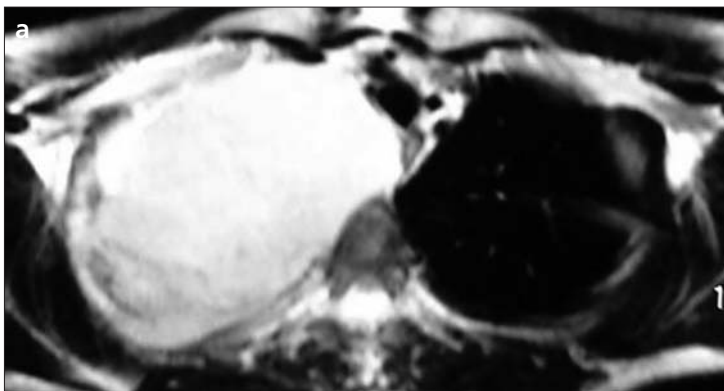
a–c. Transverse T2-weighted (a), T1-weighted (b), and contrast-enhanced fat-suppressed T1-weighted (c) MR images. T2-weighted MR image (a) shows a large mass of heterogeneous high signal intensity in the right hemithorax. The mass is hypointense on transverse T1-weighted image (b), and shows moderate enhancement on contrast-enhanced fat-suppressed T1-weighted image (c).
